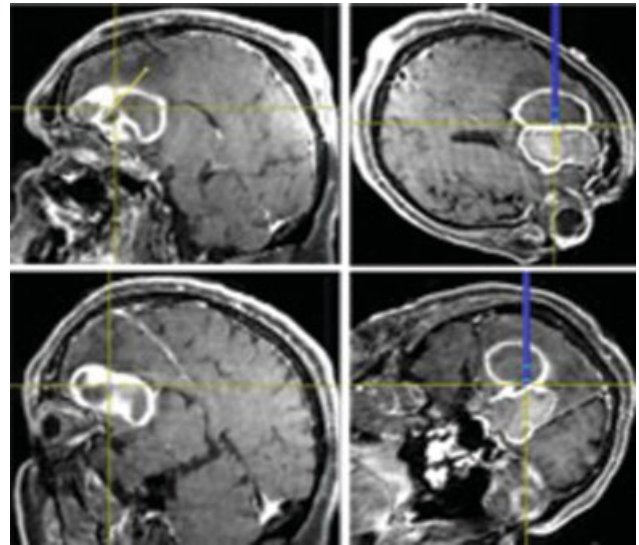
T1 MRI with intraoperative neuronavigation tracks.
